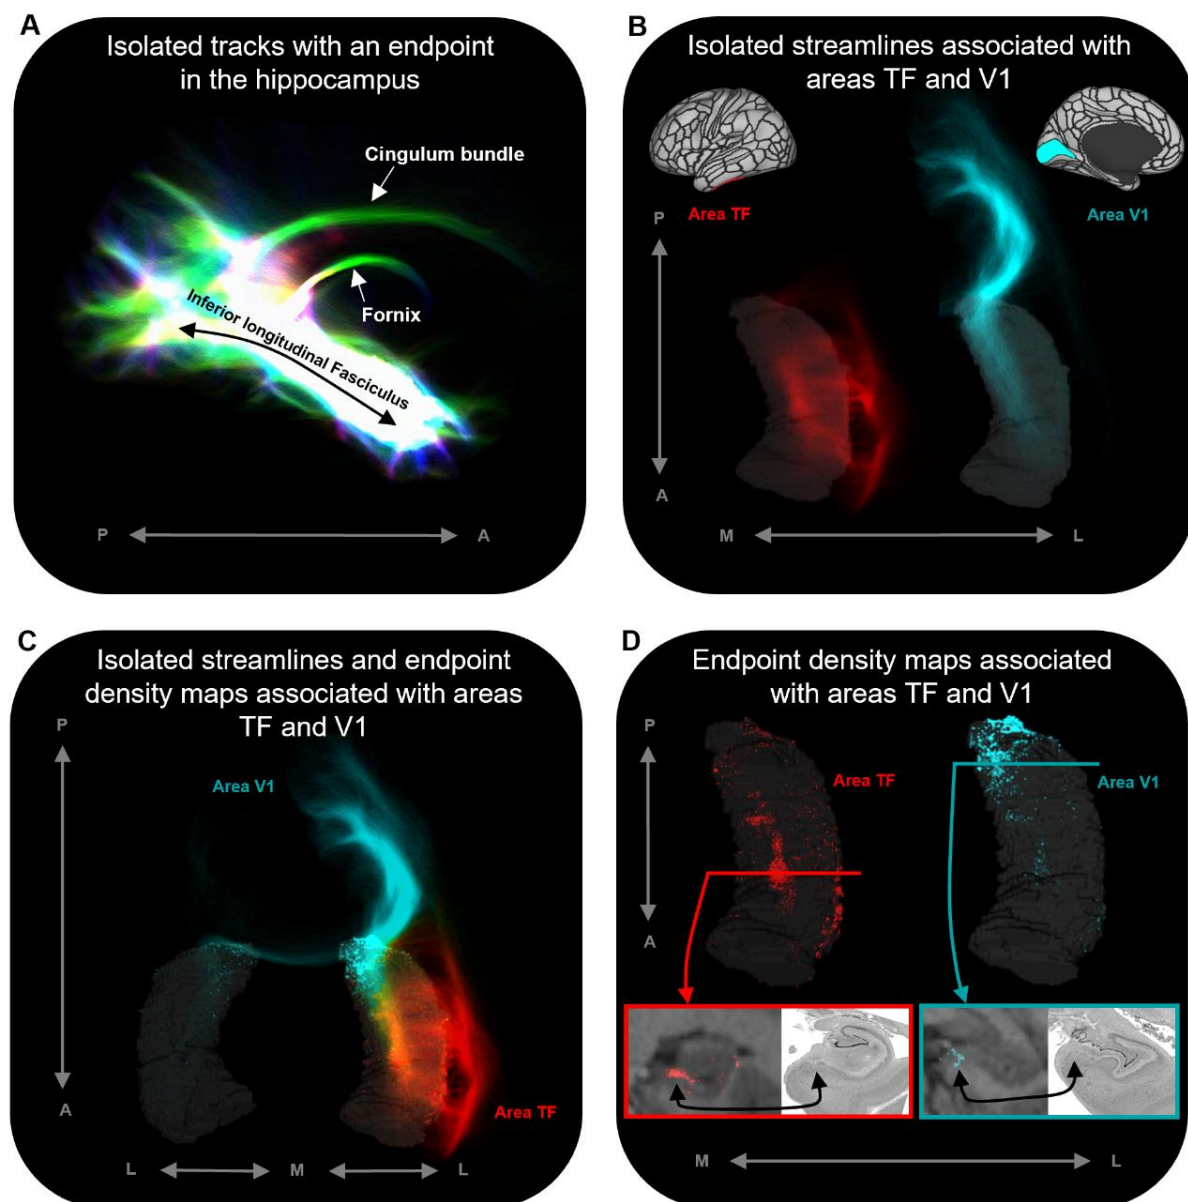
Representative examples of single subject analysis. a. 3D rendering of the hippocampus tractogram for a single participant showing isolated tracks with an endpoint in the hippocampus viewed in the sagittal plane (displayed with transparency; high intensity represents high density of tracks). b. 3D rendered left hippocampus masks (transparent grey) for the same participant overlaid with isolated streamlines associated with the left hemisphere areas TF (red) and V1 (turquoise). The location of areas TF and V1 are indicated on the brain maps (top). c. 3D rendered bilateral hippocampus mask for the same participant (transparent grey) overlaid with isolated streamlines and endpoint density maps associated with the left hemisphere areas TF (red) and V1 (turquoise). Note, while streamlines associated with areas TF and V1 are primarily ipsilateral in nature, streamlines associated with V1 also project to the contralateral hippocampus. d. 3D rendered left hippocampus masks (transparent grey) for the same participant overlaid with endpoint density maps associated with areas TF (red) and V1 (turquoise). For TF and V1, we present a coronal section of the T1-weighted structural image overlaid with the endpoint density maps and a corresponding slice of post-mortem hippocampal tissue (from a different subject) for anatomical comparison (bottom). For both TF (red border; level of the uncus apex) and V1 (turquoise border; level of the hippocampal tail), endpoint density is primarily localised to a circumscribed region in the medial hippocampus aligning with the location of the distal
